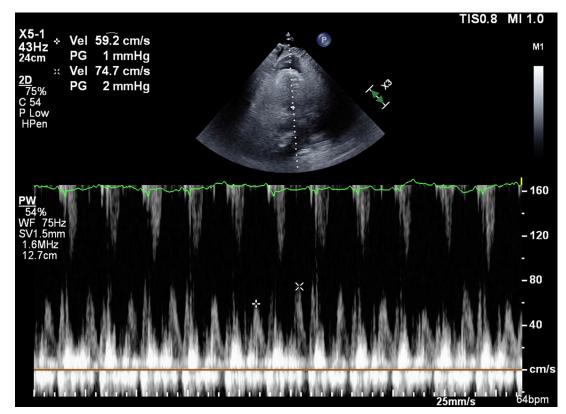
Apical four-chamber view on TTE. Pulsed-wave Doppler shows a 20% decrease in peak mitral E wave inflow velocities between inspiration (+) and expiration (x).
